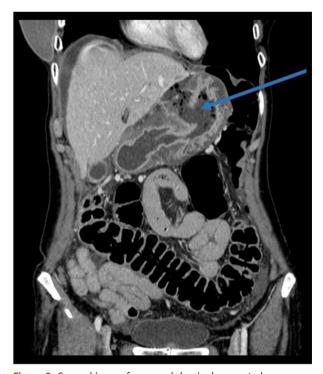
Coronal image from an abdominal computed tomography (CT) scan in a 58-year-old Lebanese woman who presented with acute gastric perforation due to metastatic ductal carcinoma 18 years following bilateral mastectomy. The arrow shows the site of gastric perforation.
